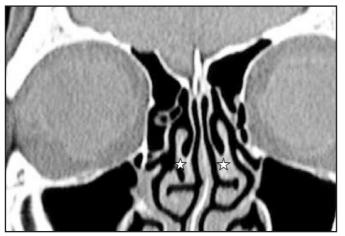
Coronal CT at the level of OMC shows bilateral paradoxical turbinates (star).
